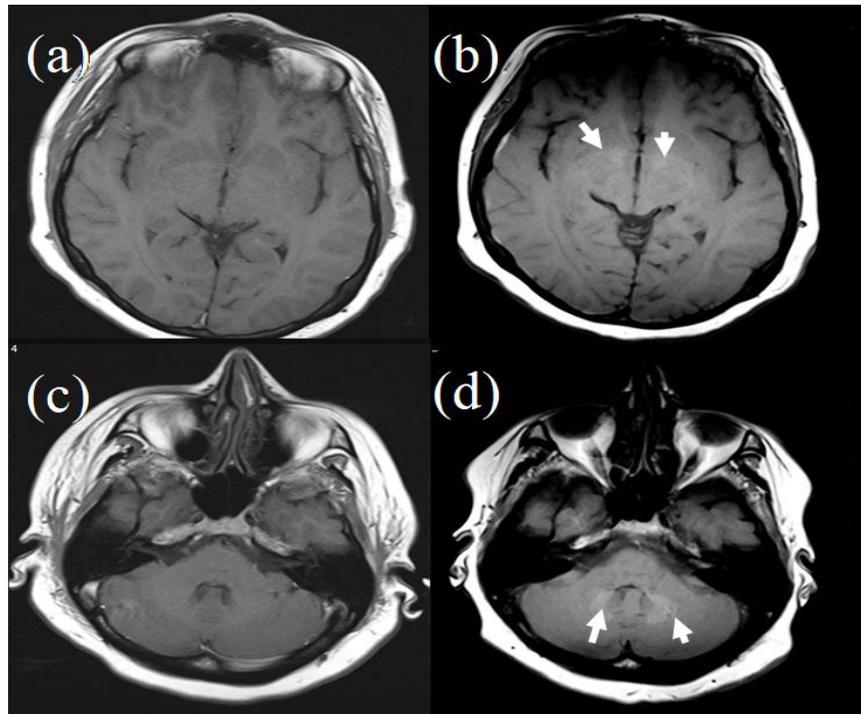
MRI T1-weighted images of a patient. (a) and (c) represent initial images and (b) and (d) after several contrast enhanced studies. Arrows in (b) and (d) show high T1 signal in globi pallidi and dentate nuclei respectively, attributed to Gadolinium deposition. Case courtesy of Prof Alan Coulthard, Radiopaedia.org, rID: 38904. Modified from original images (50).
